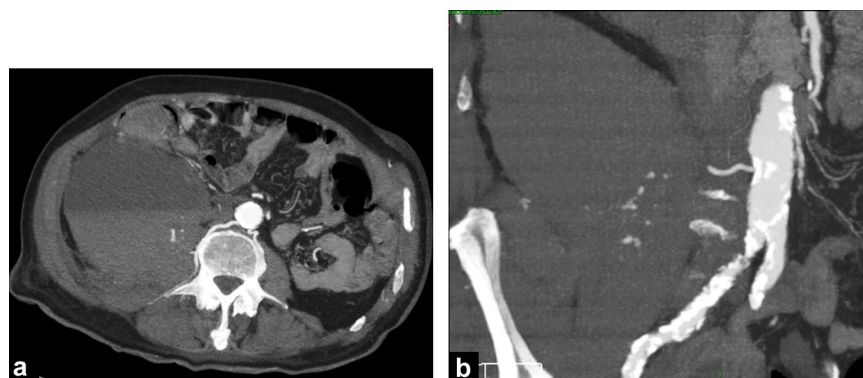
Computed tomography (CT) angiography of a 72-year-old patient with hemodynamic shock. This patient has taken an overdose of anticoagulants. CT angiography reveals a voluminous hematoma of the right psoas muscle with an active leak of contrast material (a). Oblique coronal MIP reconstruction (3 mm thick) identifies the right L4 artery as the source of the hemorrhage (b).
